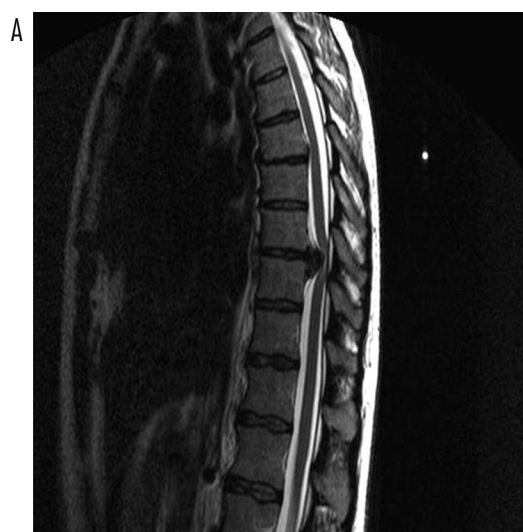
MRI before and CT after thoracic discectomy by thoracotomy
